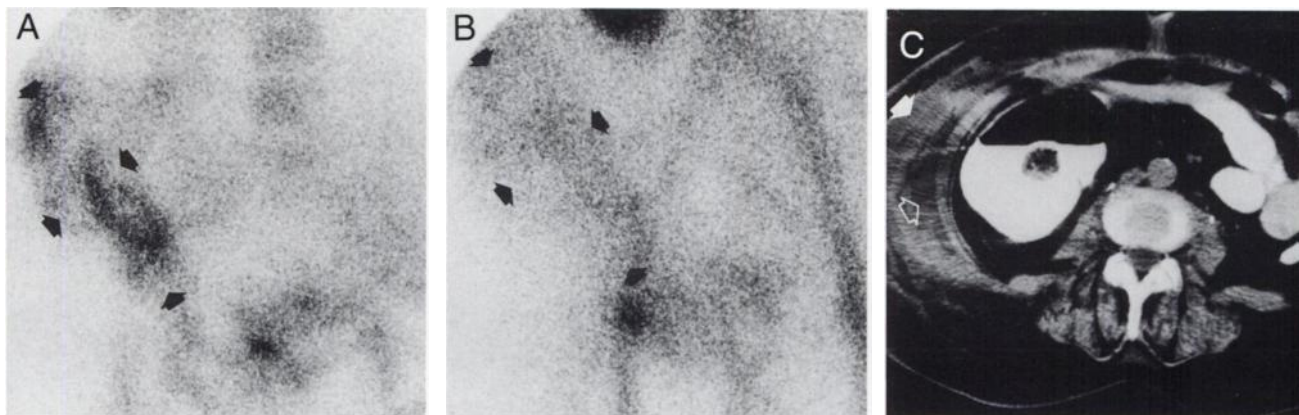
Postoperative cellulitis and abscess. (A) ^{99m}Tc leukocyte scan at 4 hr showing stronger accumulation of tracer, lesion better delineated than in ^{99m}Tc -HIG scan at 5 hr (B). Arrows indicating the corresponding areas. (C) CT scan revealing edema (closed arrow) and a small collection of fluid (open arrow) in the abdominal wall.
